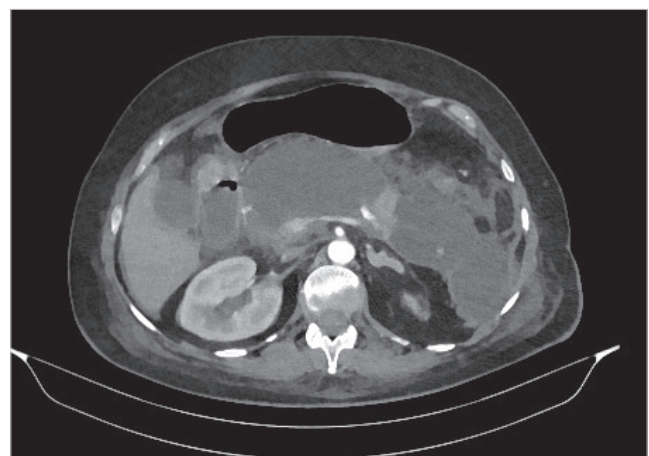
CT scan. Acute necrotizing pancreatitis associated with CMV.
